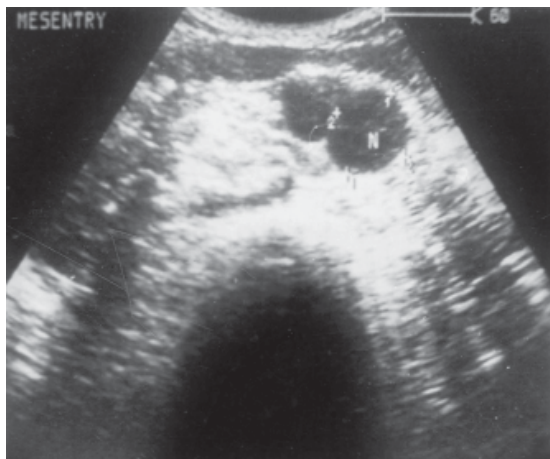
Abdominal ultrasonography showing enlarged mesenteric lymph nodes (Note the hypoechoic centers due to caseation)
